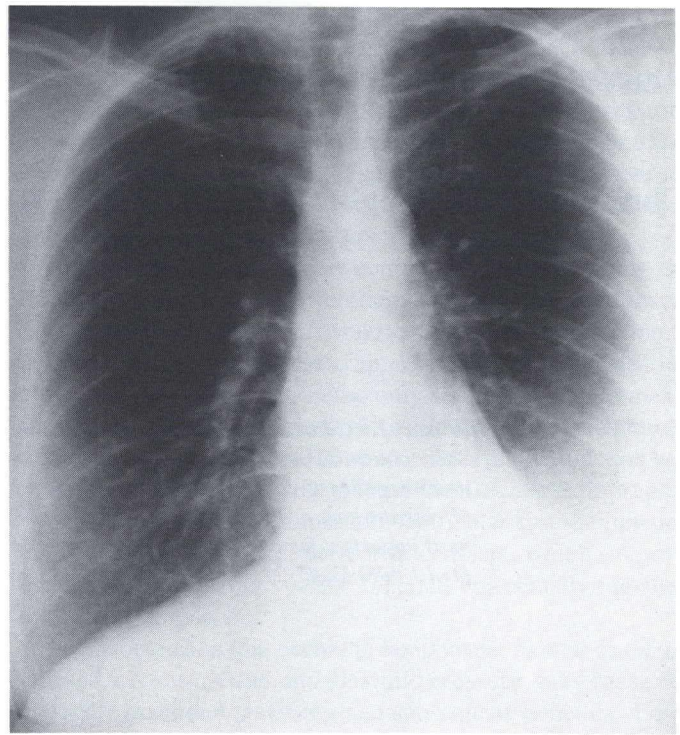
Chest x-ray two months after initial presentation revealing moderate left pleural effusion.
